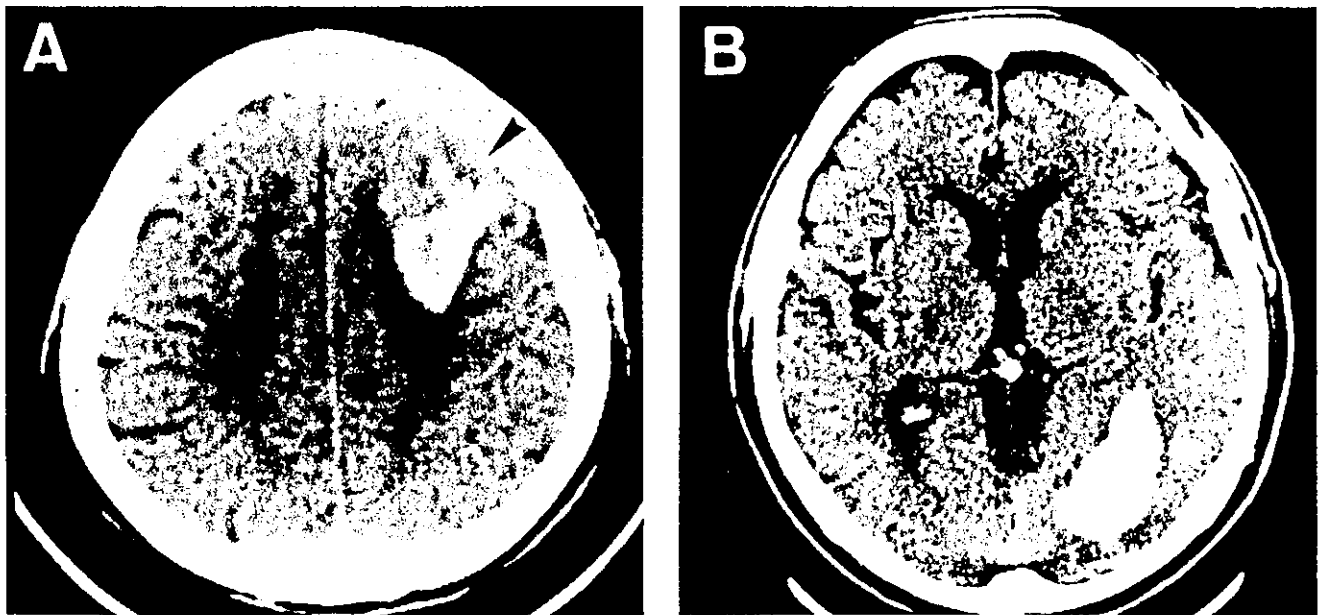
Representative CT findings in patients with and without subarachnoid extension, (A) and (B), respectively. Note extension of the hematoma into the subarachnoid space (arrowhead).
